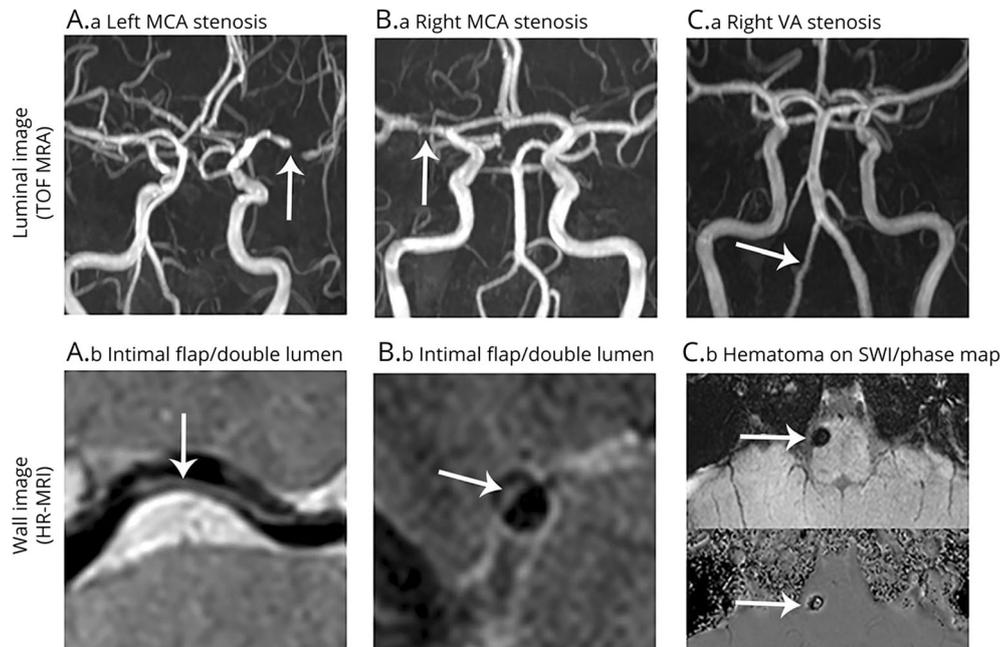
Reprinted with permission from Shin et al., American Academy of Neurology [41••]. “Examples of patients with no typical changes of dissection on luminal imaging (A.a, B.a, C.a, arrows) but with high-resolution MRI findings of dissection (A.b, B.b, C.b, arrows).”
